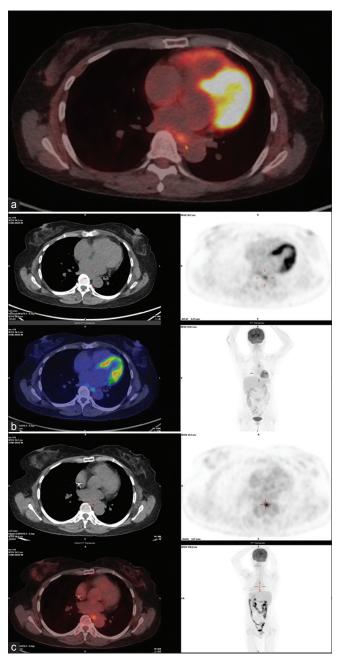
Positron emission tomography/computed tomography (PET/CT) imaging before and after treatment. (a) Baseline (pretreatment, August 2023): High-grade fluorodeoxyglucose (FDG)-avid lymphadenopathy in multiple regions, including the middle thoracic esophagus (arrow), gastrohepatic ligament, hepatoduodenal ligament, celiac, right retrocrural, paraaortic, aortocaval, paracaval, and bilateral common iliac regions, consistent with metastatic lymph node involvement, (b) Posttreatment (December 21, 2023): Complete metabolic response (CR) in prior FDG-avid lymph nodes. Low-grade FDG uptake in the lower esophagus suggested posttherapeutic inflammation rather than recurrence (~4-month interval), (c) PET/CT (May 30, 2024): New focal high-grade FDG uptake (maximum standardized uptake value: from 6.3 to 8.0) in the midthoracic esophagus (arrow), raising the suspicion of recurrence (~5-month interval from prior CR)
